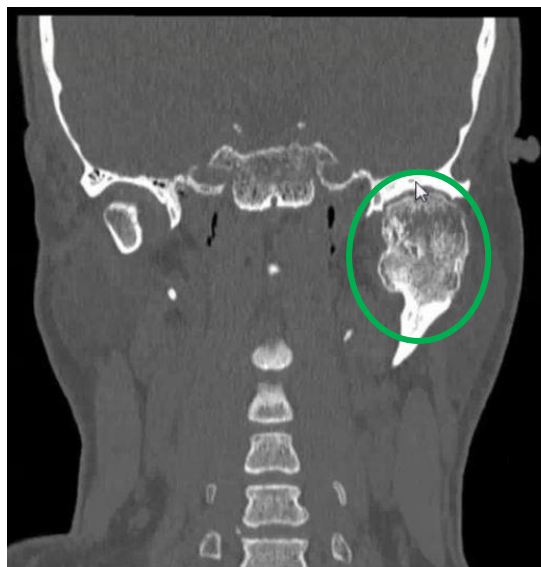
Computed tomography, coronal view. Proliferative lesion of the left TMJ inside the green circle (RadiAnt DICOM Viewer 2025.2).
